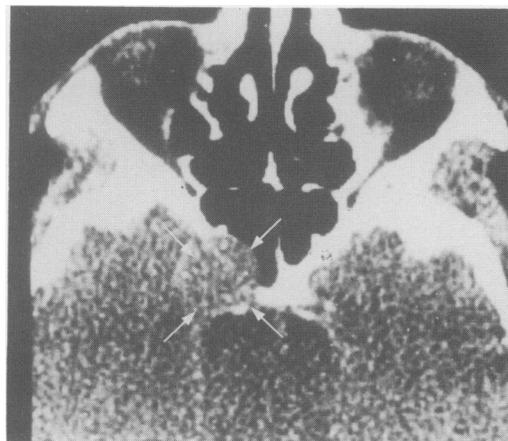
CT scan. A mass can be observed, located in the left cavernous sinus and invading the sella turcica (arrows).
